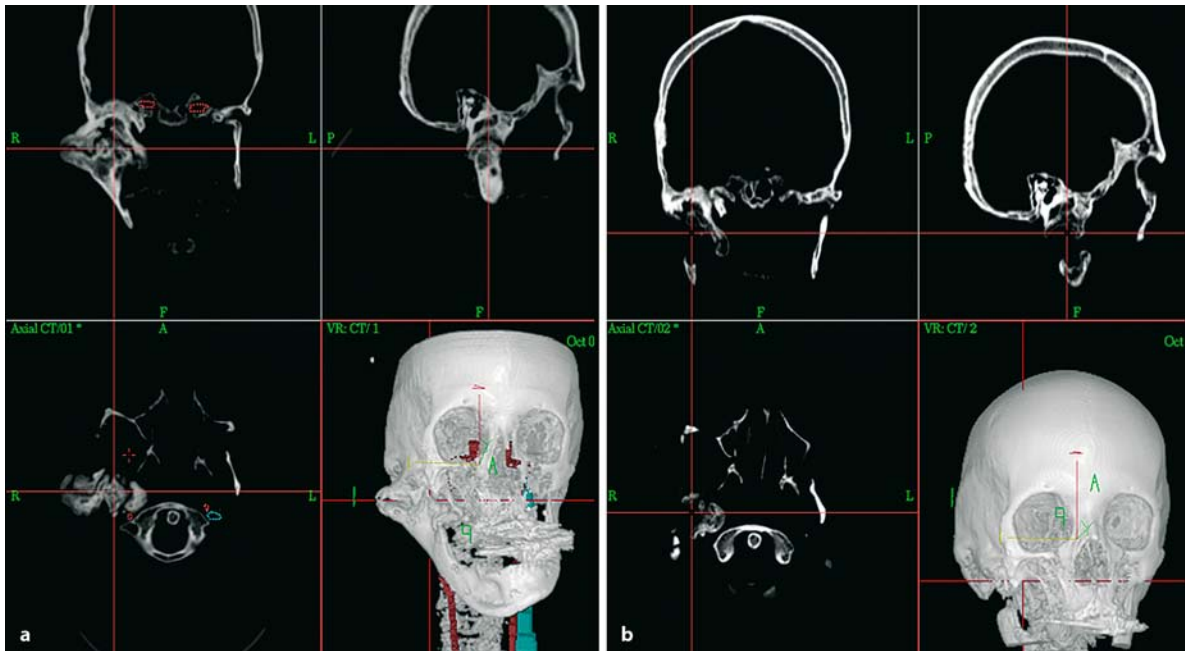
Postoperative evaluation of a navigation-assisted contouring osteotomy of the lateral skull base (fibrous dysplasia). The preoperative (a) and postoperative CT data sets (b)
